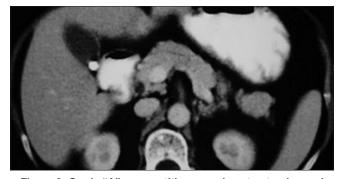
Grade "A" pancreatitis; normal contrast-enhanced computed tomography morphology of pancreas with elevated serum amylase. Incidental gallbladder calculus noted
